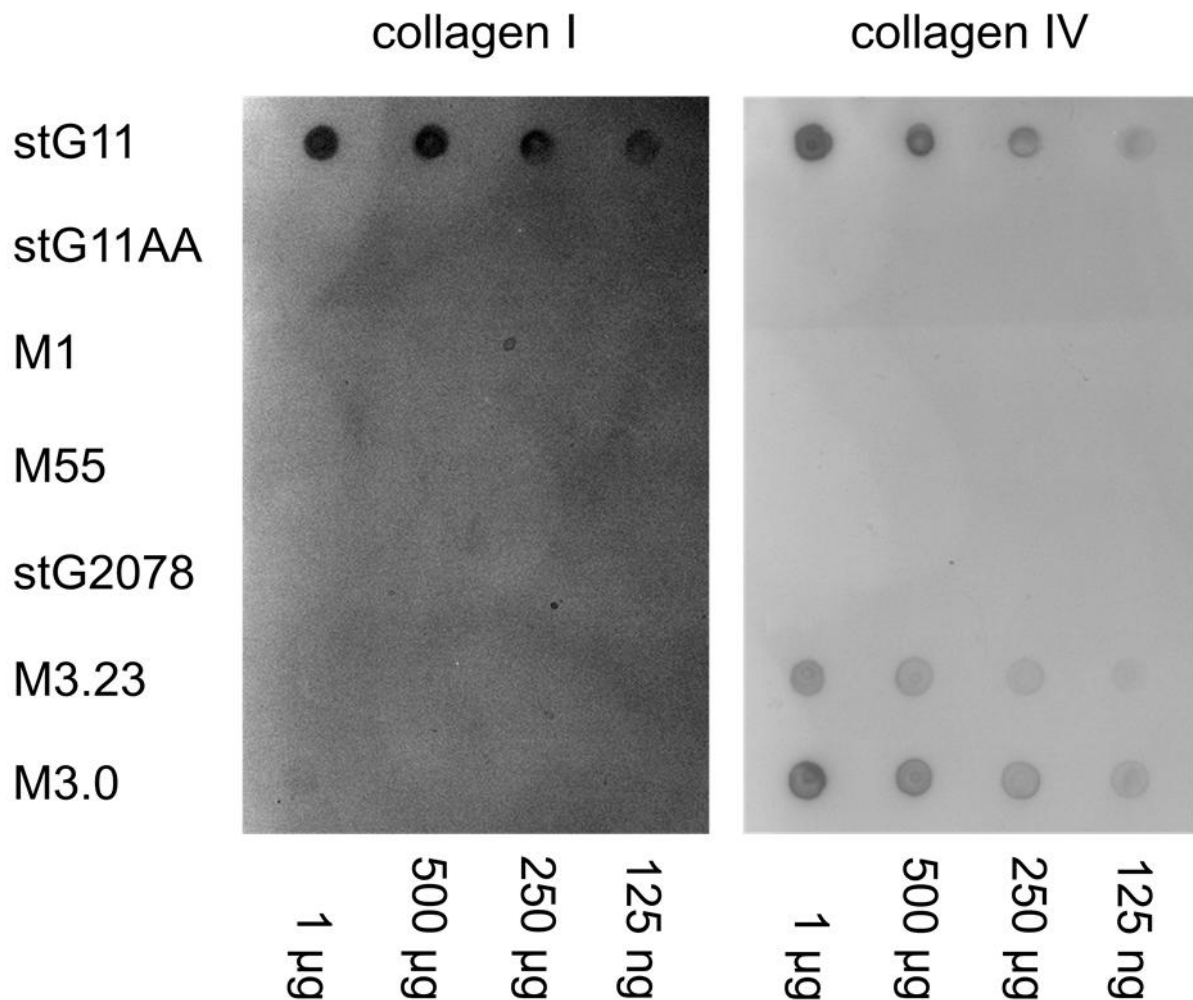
Binding of collagen I and IV to M proteins in a ligand overlay assay. Binding of radiolabelled collagen I (*left*) and collagen IV (*right*) to immobilized M proteins that are indicated on the *left*, was detected radiographically. Amounts of immobilized M protein are indicated below. Only a weak signal for binding of collagen I to M3.0 at 1 μ g could be detected.
